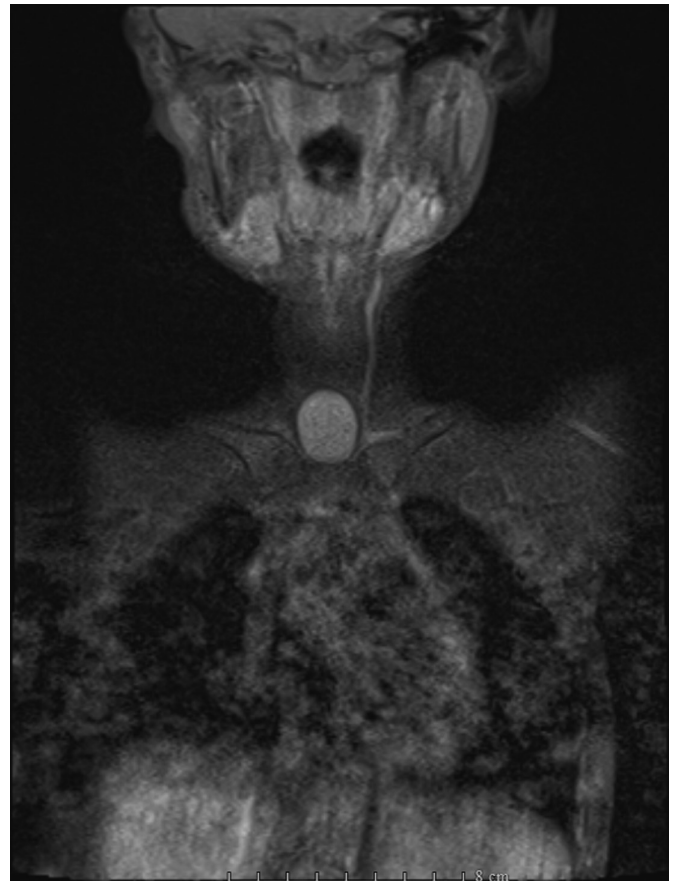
Coronal T1-weighted Dixon MRI of the cystic structure. MRI, magnetic resonance imaging.
